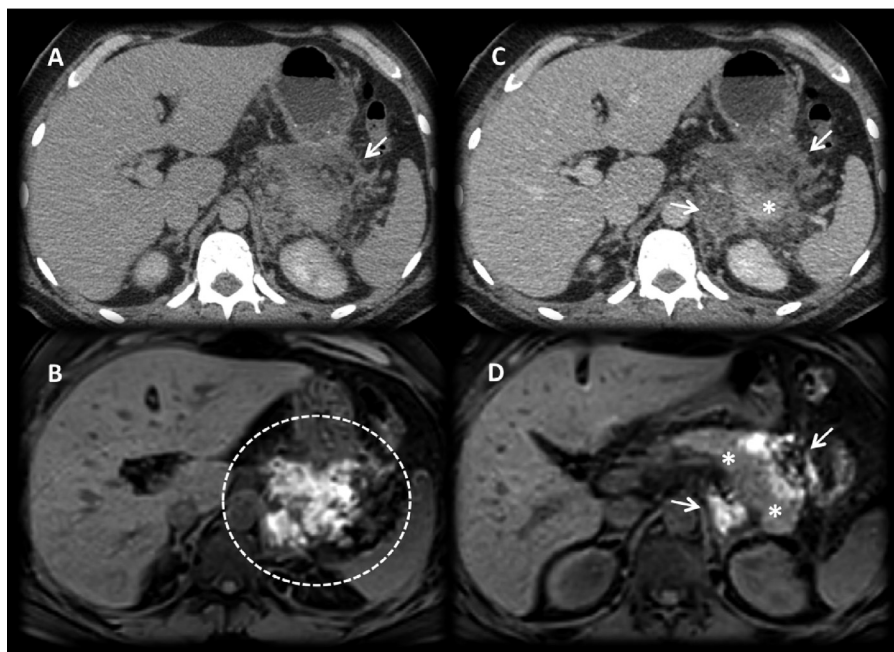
Early NAP with isolated extrapancreatic necrosis. (A, C) CECT demonstrates peripancreatic soft tissue necrosis. Note the tiny dots of macroscopic fat tissue within the hypodense collection (arrows), resembling a "cobblestone" appearance of the necrosis, a very useful sign to depict early extrapancreatic fat necrosis. (B, D) T1 Weighted suppressed MRI confirms heterogeneous hyperintensity of the peripancreatic soft tissue (circle and arrows), consistent with extrapancreatic necrosis. No necrosis of the remaining pancreatic parenchyma is observed (*).
